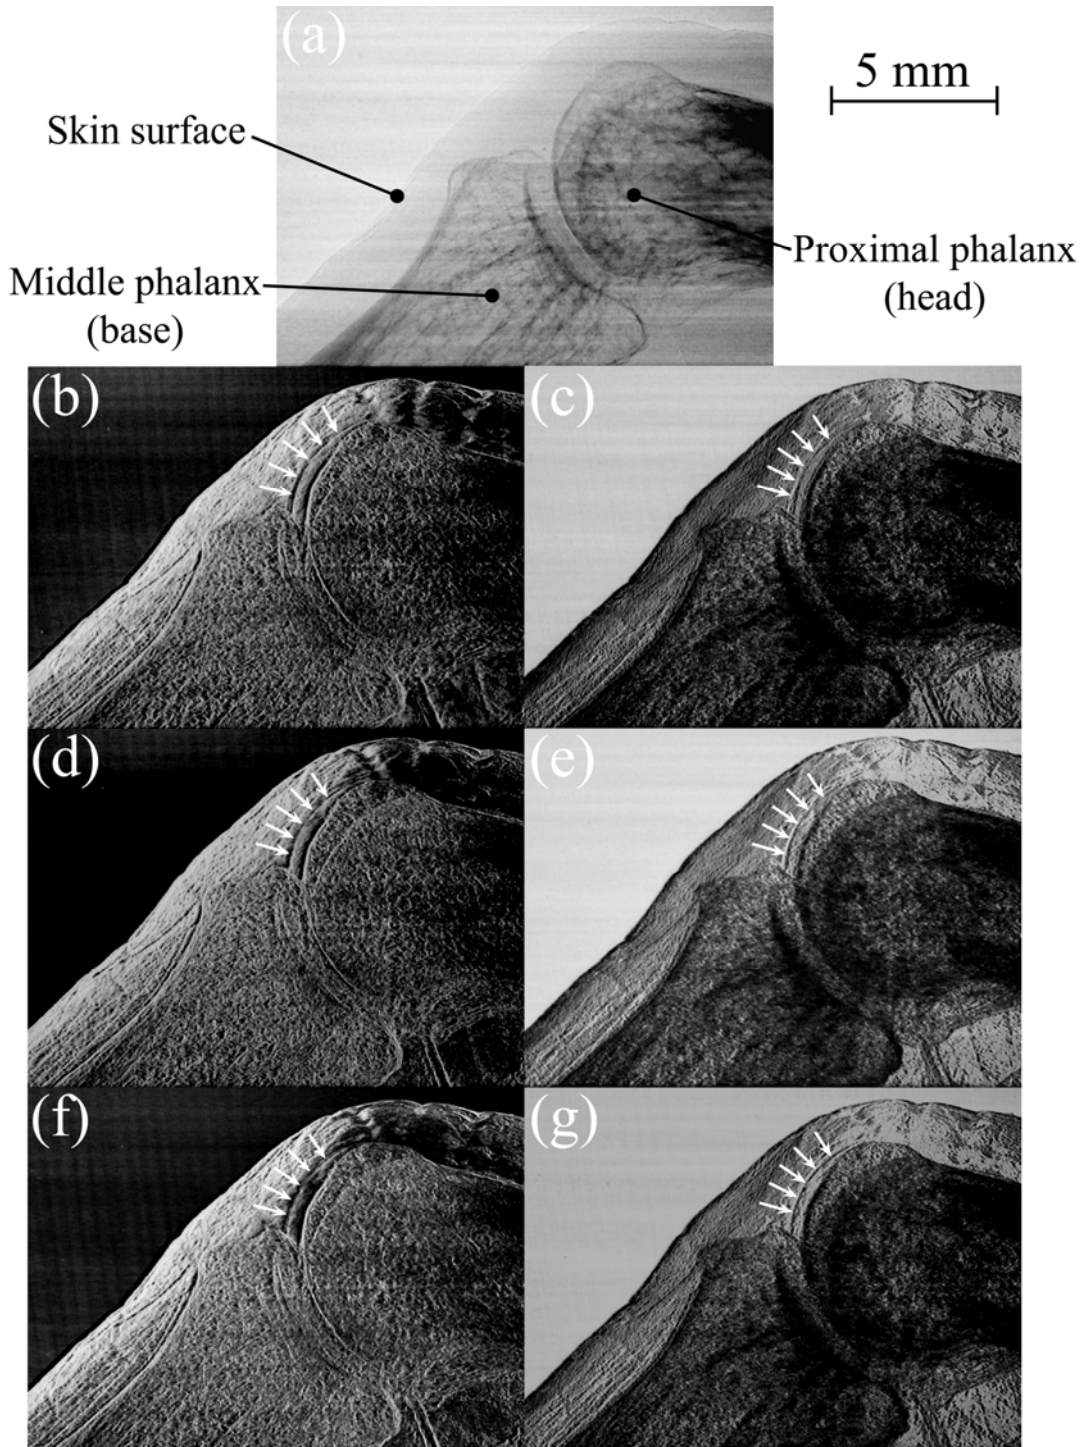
X-ray images of PIP joint taken at BL14B as a preliminary experiment. White arrows indicate articular cartilage on the head of the proximal phalanx.
